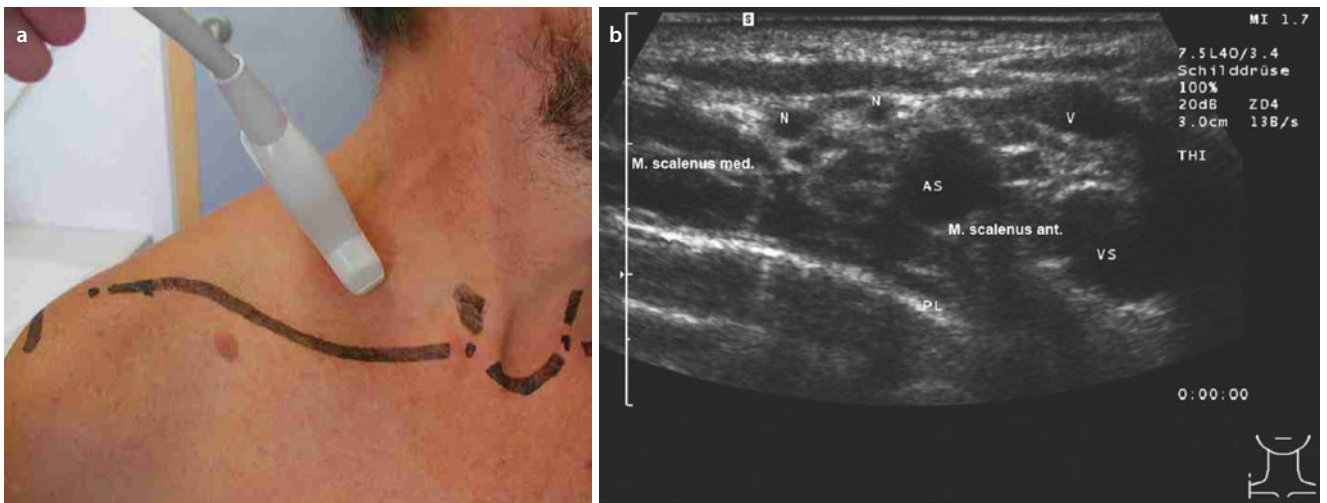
Investigation of the upper thoracic aperture. a Semisagittal longitudinal section at the base of the lateral cervical region. b Corresponding ultrasound image. AS subclavian artery, VS subclavian vein, PL pleura, N branches of the brachial plexus, V innominate vein
